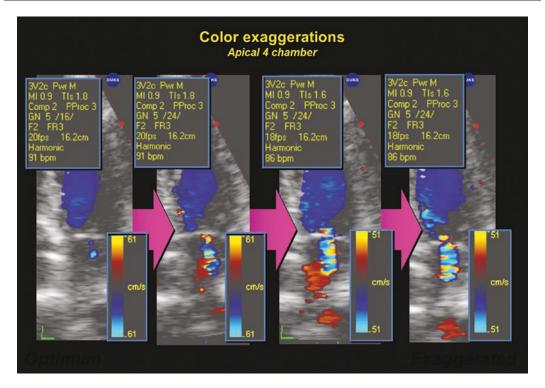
The size of the trivial mitral regurgitant jet is again increased in this image from the apical four-chamber view by use of improper settings. The machine used here
